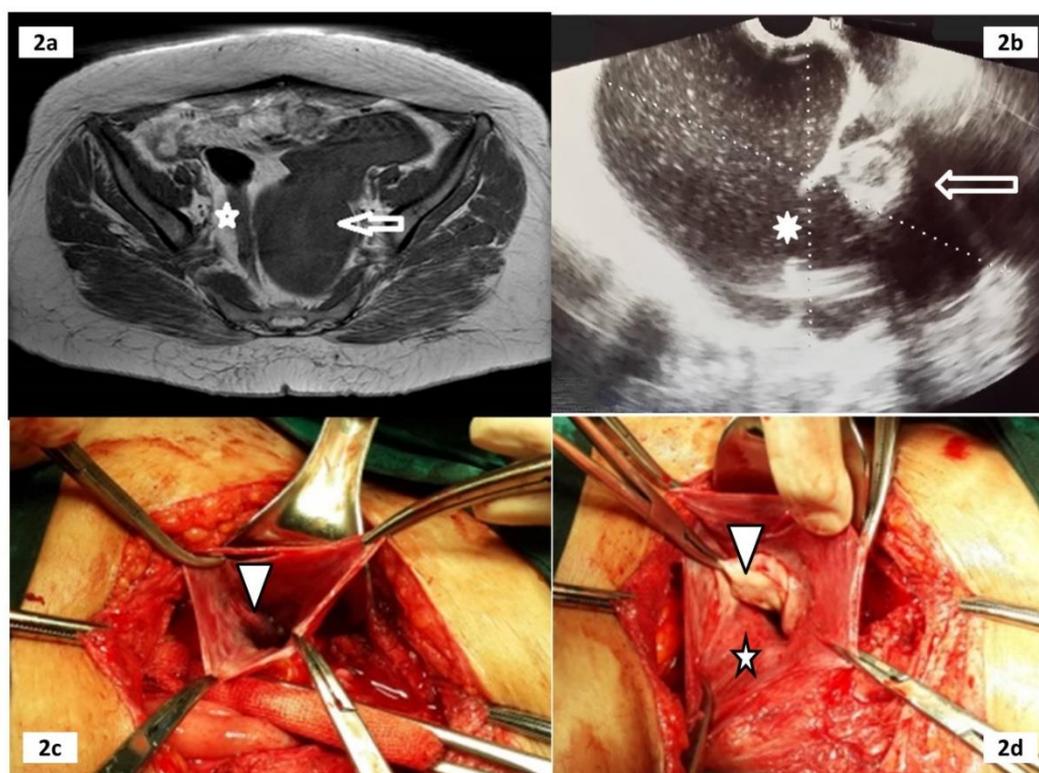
2a: A magnetic resonance image of a 14x12cm left pelvic peritoneal cyst (PC) that belongs to a premenopausal woman hysterectomized 3 years ago. The arrow indicates the cyst and the asterisk indicates the rectum. 2b: The left pelvic PC with “spider in web” appearance of ultrasound image (arrow and asterisk). 2c: The cyst wall was incised. An inside look into the PC. The ovary is located deeply in the cyst, arrowhead shows the ovary. 2d: The left ovary is entrapped in a PC attached to the left pelvic side wall. The asterisk shows the ovary and the arrow head shows the PC wall.
